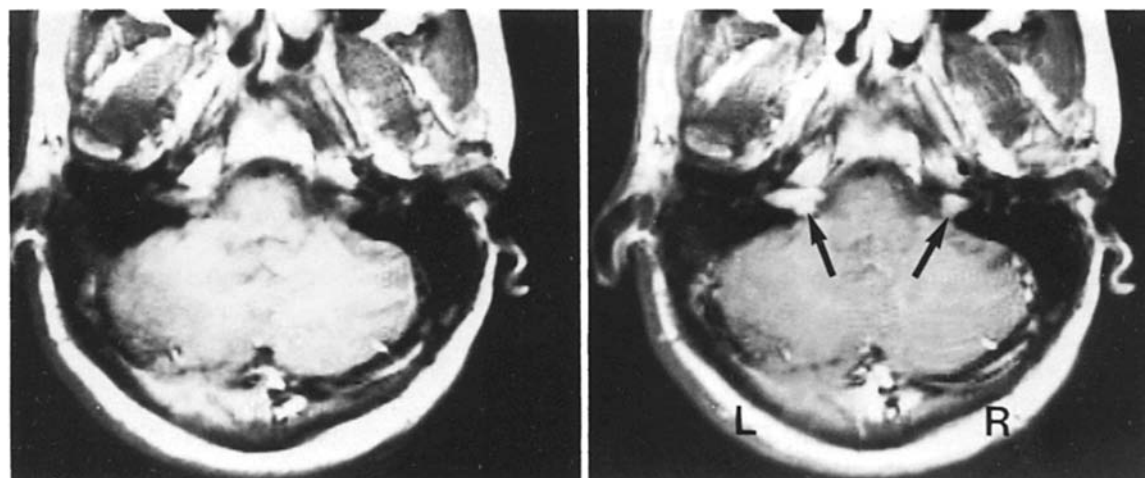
Magnetic resonance imaging of bilateral acoustic neuroma. The tumours were best shown on gadolinium-enhanced T₁-weighted images on the right (arrows; 400 ms TR, 30 ms TE). For comparison, the unenhanced scan on the left
